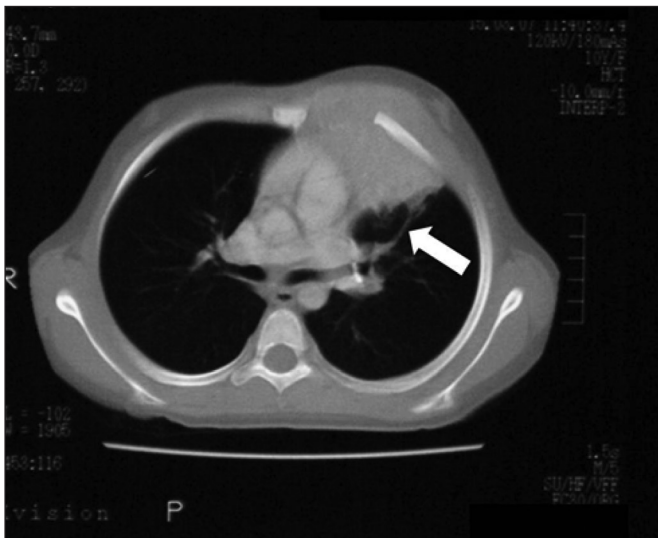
Contrast computed tomography scan showing the image of a large mass of soft tissue at the left upper lobe, expanding to the anterior mediastinum and the left anterior chest wall. The eighth rib is displaced anterolaterally (arrow)
